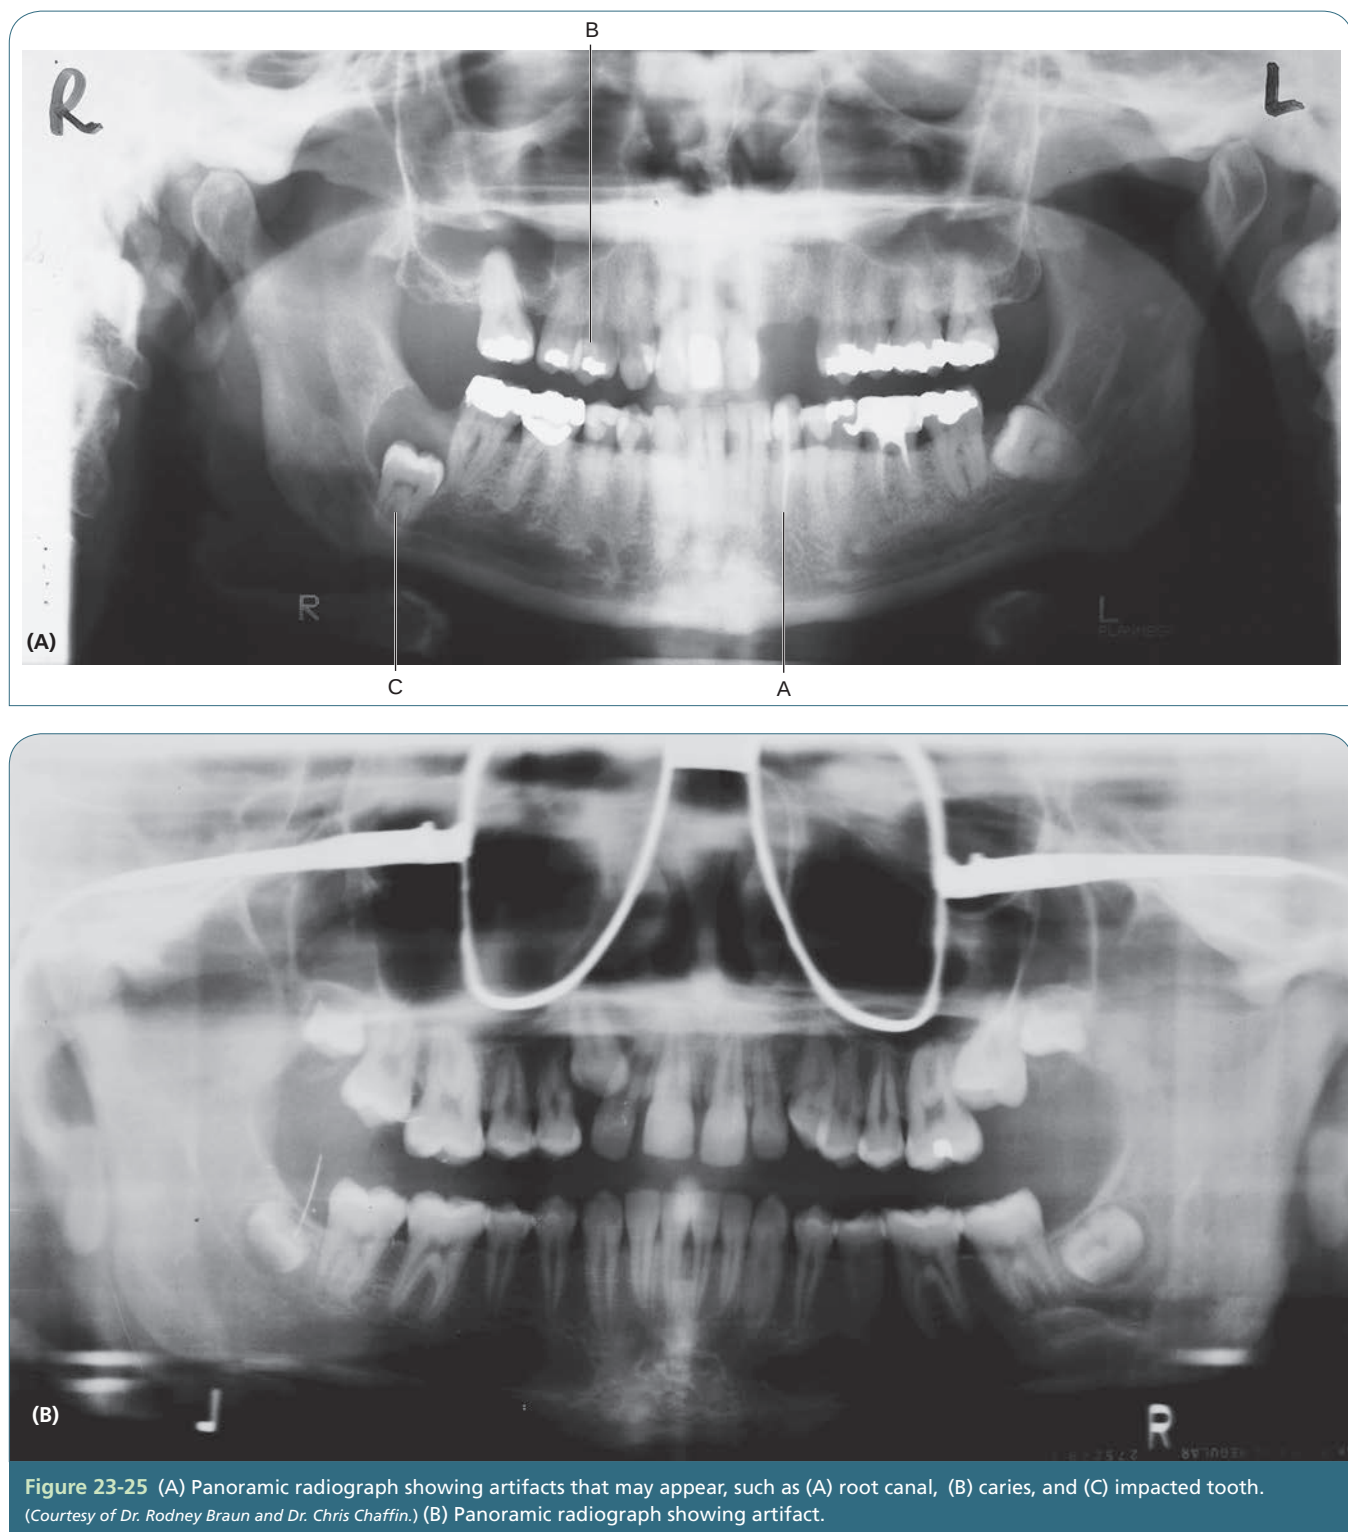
(A) Panoramic radiograph showing artifacts that may appear, such as (A) root canal, (B) caries, and (C) impacted tooth. (Courtesy of Dr. Rodney Braun and Dr. Chris Chaffin.) (B) Panoramic radiograph showing artifact.
